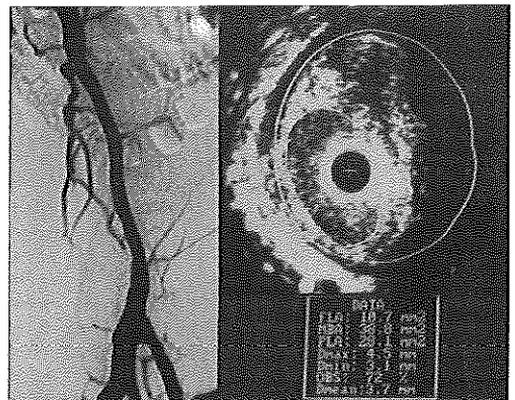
Angiogram and intravascular ultrasound cross-section of the inflow tract. A 72% stenosis of the common femoral artery evidenced by intravascular ultrasound was not seen on angiography. + = Catheter; calibration = 1 mm.
